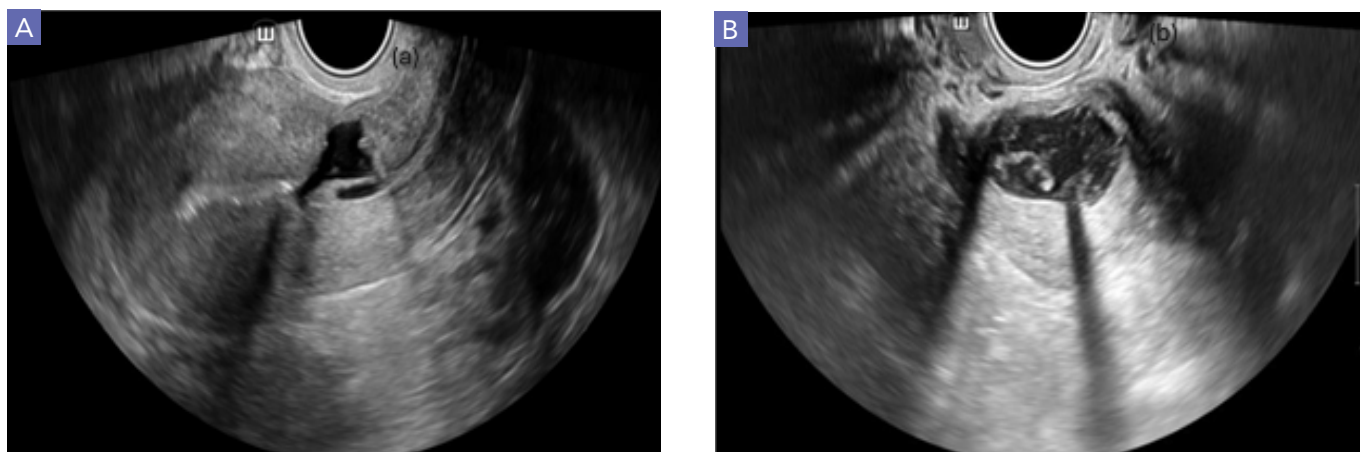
Sonographic planes needed for caesarean scar niche measurement. (A) The sagittal plane; (B) The transverse plane.
